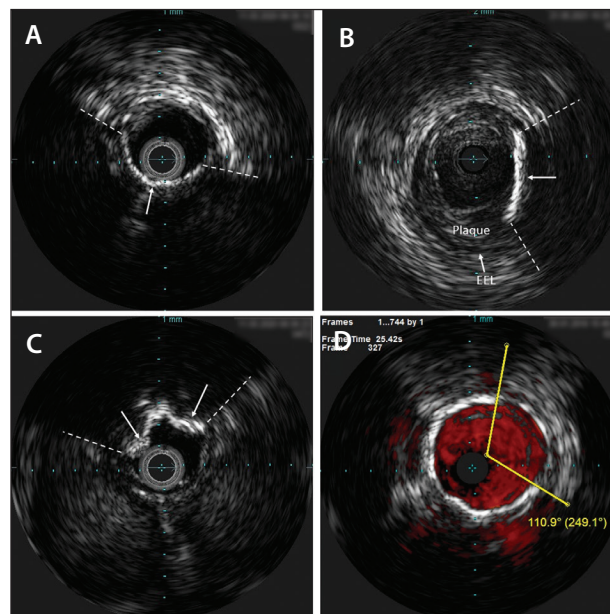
Vessel wall calcification can be recognized by intensely bright echoes (arrows) and acoustic shadow deep to the calcium (dashed lines) due to total reflection and absorption of the ultrasound beam. Medial calcification (arrow) is characterized by location within the media and smooth contour (A). Intimal calcification (arrow) is characterized by location within the plaque and superficial location relative to the vessel wall (B). Intimal calcification may have an irregular contour and may project into the lumen (arrows) (C). Calcium severity can be quantified by measuring arc of calcium around the wall (D). In this case, medial calcification extends 249° around the wall. Note that medial and intimal calcium may both be present, and shadowing from intimal calcium may obscure visualization of medial calcium.
